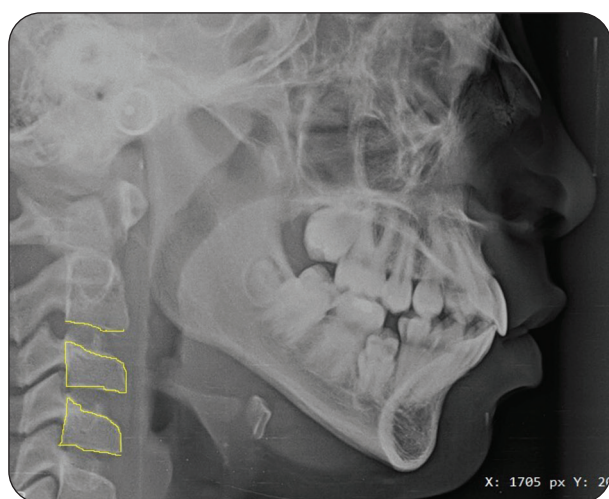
Lateral cephalometric radiograph showing free hand tracing of the inferior border of C2 dense odontoid and body of C3 and C4 using MicroDicom software
